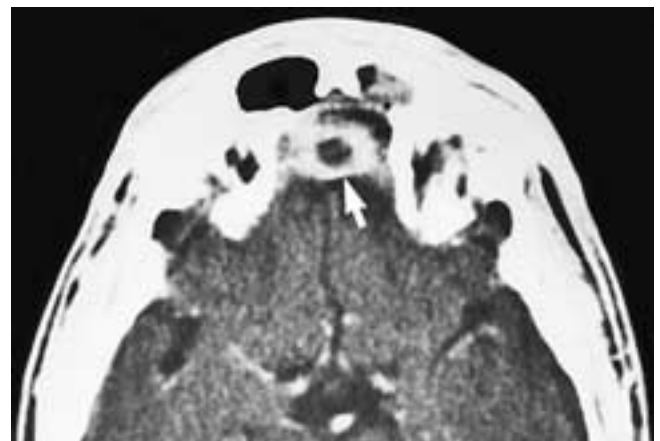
Axial contrast-enhanced CT scan shows a ring-enhancing mass (*arrow*) just cranial to the fascial-muscle graft in a patient who has had a craniofacial resection. This patient had a postoperative abscess.
